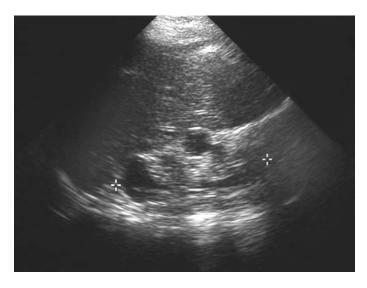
Sonogram of a 14-month-old child with a multicystic dysplastic kidney. The parenchyma is echogenic and the cysts are peripheral.
